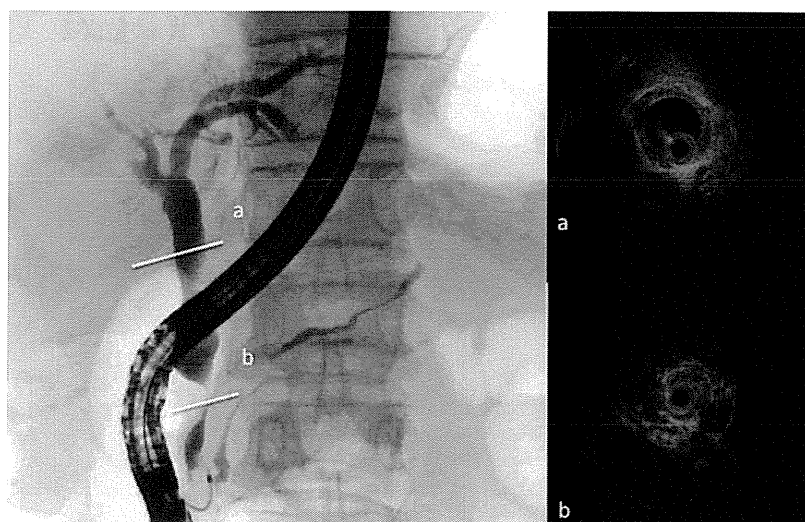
Intraductal ultrasonography (IDUS) findings. (a) In the non-stenotic portions where the cholangiogram result was normal, IDUS findings reveal wall thickening of the bile duct. (b) In the stenosis of the lower bile duct, IDUS findings also reveal wall thickening.
